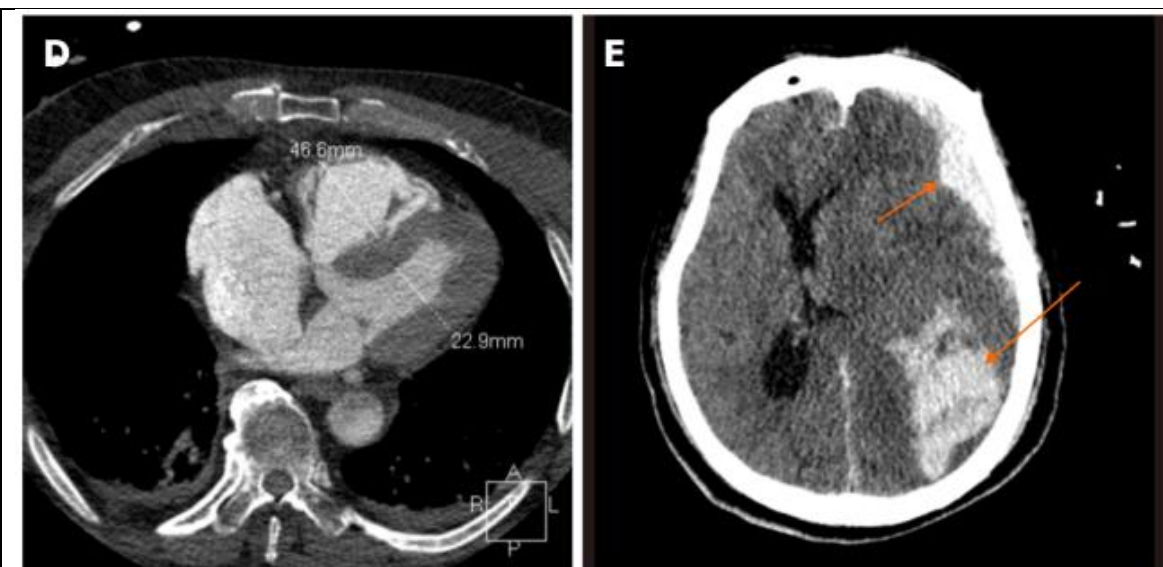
D) 46.6 mm right ventricle dilation as shown in CECT; E) CT scan reveals left frontal, parietal, and subarachnoid hemorrhage (orange arrows).
